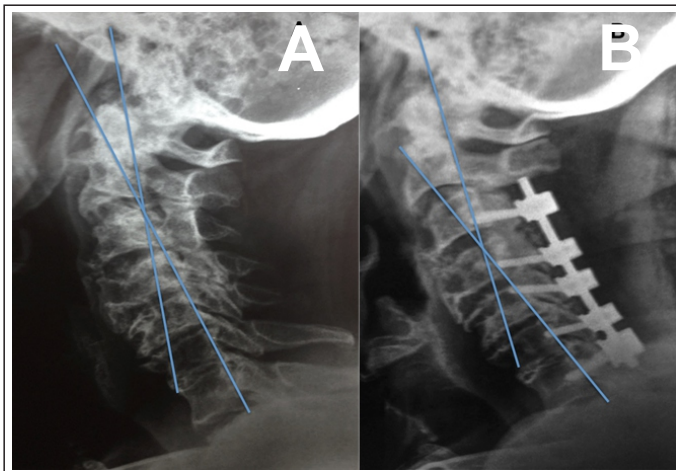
Shows measurement of cervical lordosis using posterior tangent line through the posterior body of C2 and C7 in (A) preoperative 16 degrees which improved (B) postoperatively to 22 degrees on cervical lateral x-rays.
